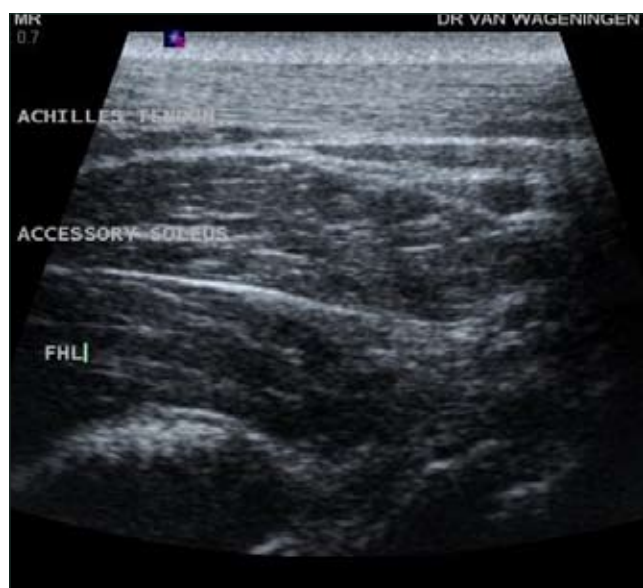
Ultrasound of left accessory soleus muscle: same echogenicity and appearance as the underlying flexor hallucis longus muscle.
